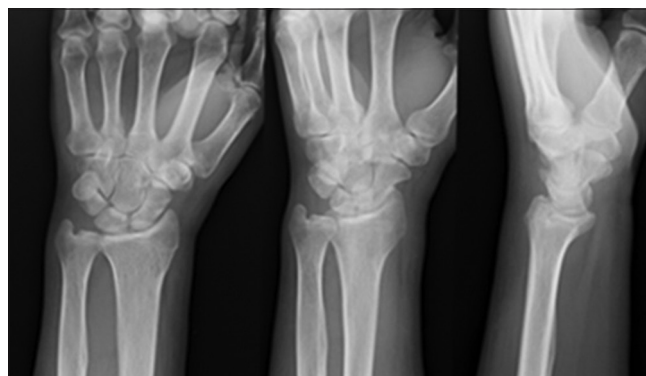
Post-injury X-ray of the left wrist, interpreted by the radiologist as unremarkable
